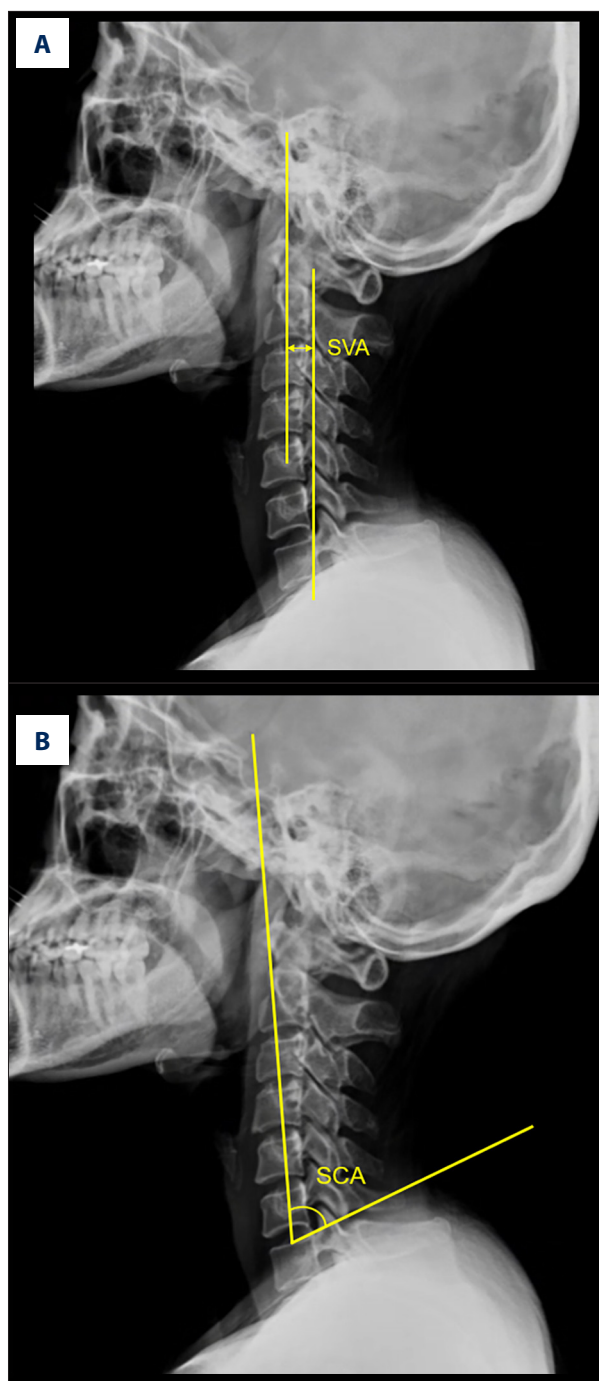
Measurements of cervical sagittal radiographic parameters on lateral cervical radiographs. (A) The sagittal vertical axis (SVA) was measured as the horizontal distance from a vertical line drawn from the centroid of the C2 vertebral body to the posterosuperior corner of the C7 vertebral body, reflecting the anterior–posterior translation of the cervical spine. (B) The spino–cranial angle (SCA) was measured as the angle between a line connecting the center of the sella turcica to the center of C7 and a line along the posterior aspect of the cervical vertebral bodies, providing an index of the overall sagittal curvature relative to the cranial base. (C) Intervertebral disc height was measured as the average of the anterior and posterior disc heights at each cervical level from C2–C3 through C6–C7, with measurements taken at the midpoint of each vertebral segment.
